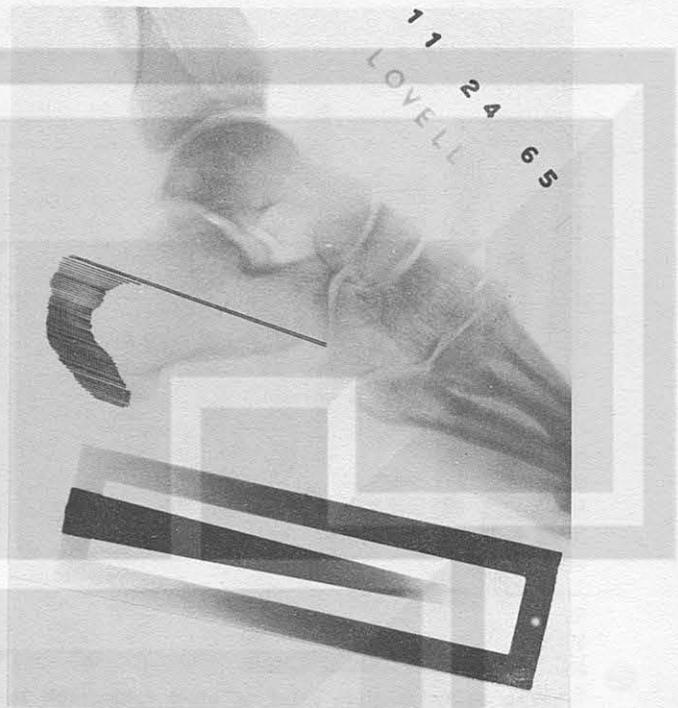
Positive print of radiograph of os calcis showing location of the multiple sections which are evaluated. These scans are made entirely across the bone, parallel with the conventional section. They are 1 millimeter wide from the center of one scan to the center of the next scan, and hence they cover all of the 60 percent of this bone which is involved in this evaluation.
